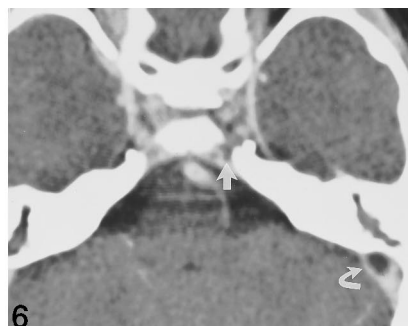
Axial contrast-enhanced CT scan in 4-year-old boy with acute mastoiditis and subgaleal abscess on the left. Note multiple small partially confluent filling defects within the cavernous sinus bilaterally and left sigmoid sinus thrombosis (curved arrow). Note thrombus extension from left cavernous sinus to junction with inferior petrosal sinus (straight arrow).
